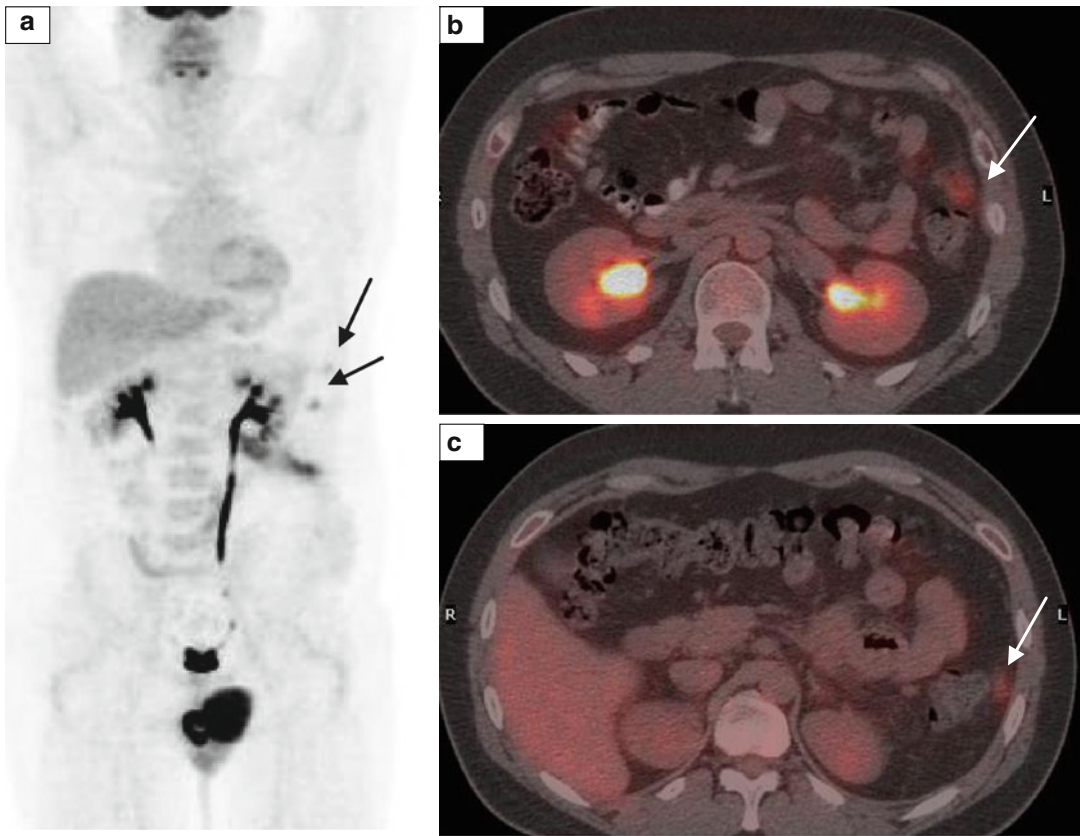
(a–c) MIP-PET and fused PET/CT post splenectomy: Two nodules (*arrows*) with mildly increased uptake of the radiopharmaceutical at the left paracolic area in contact with the omentum
